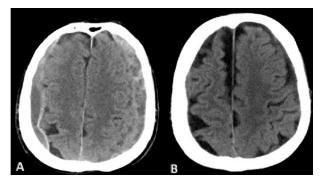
A 76 male on regular antiplatelets. (A) Preembolization computerized tomography (CT) scan showed bilateral chronic subdural hematoma, (B) 6 months post upfront - embolization CT scan showed complete resolution of the bilateral chronic subdural hematoma.
